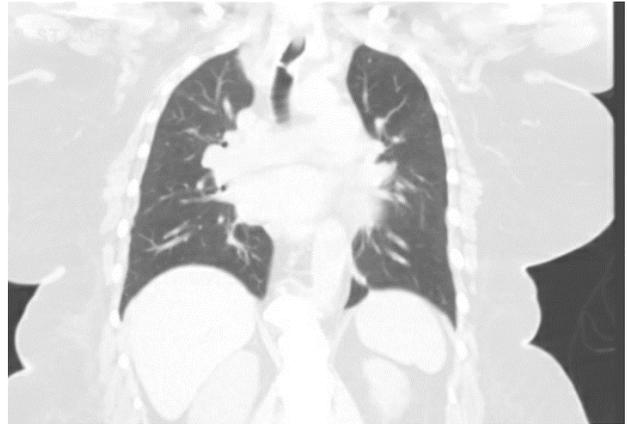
Coronal section of high-resolution CT scan of the chest showing bilateral ground-glass opacities highly suggestive of COVID-19.
